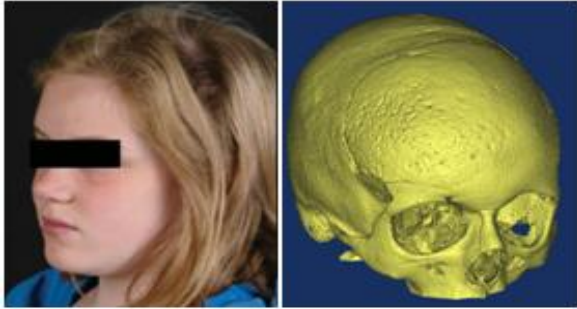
Clinical appearance at 10 months post-surgery. Right: CT at 40 months showing excellent osteointegration and aesthetic results.
